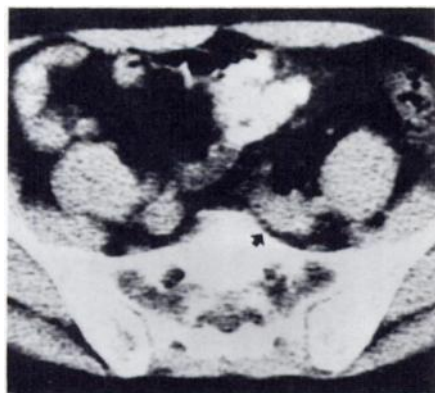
False-positive CT: Soft-tissue prominence in left common iliac region (arrow). Nodes were negative at surgery. In retrospect, this finding was secondary to prominent vascularity.
